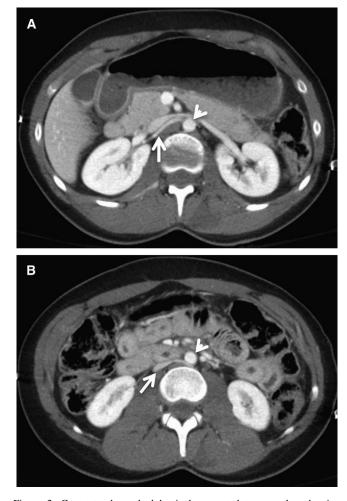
Contrast-enhanced abdominal computed tomography, showing several features of the hypovolemic shock complex, including flattened inferior vena cava (arrows) at (A) and 2 cm below (B) renal arteries. A narrow calibre aorta (9 mm) is also demonstrated at these levels (arrow-heads). There also is diffuse small bowel wall thickening and enhancement in addition to dense renal cortical enhancement.
